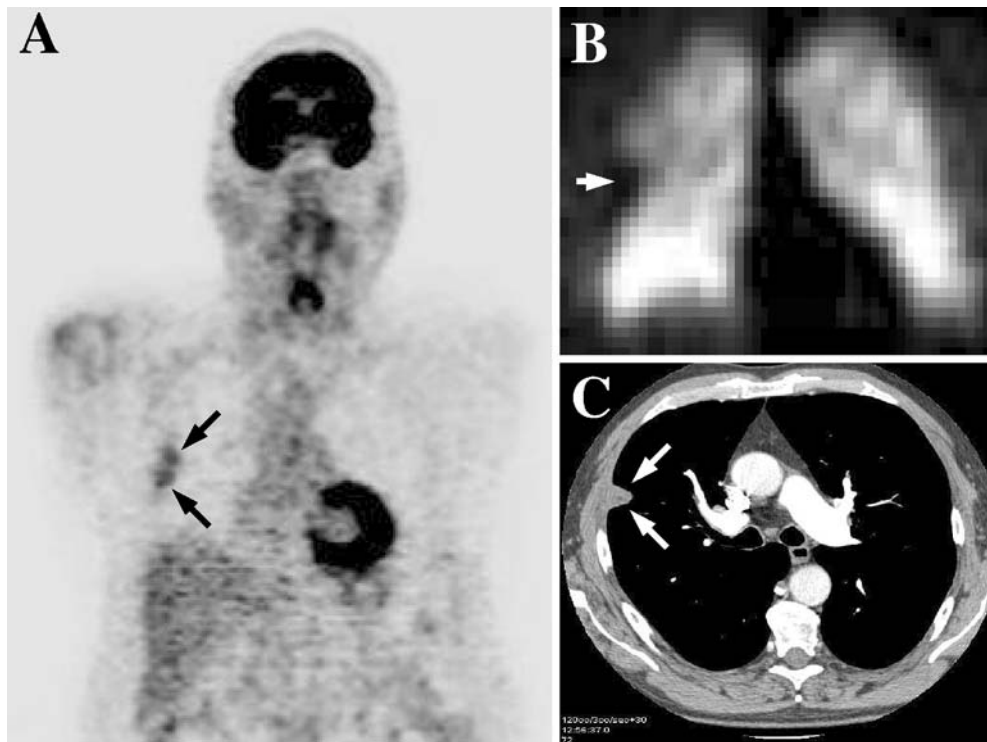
A Coronal FDG PET in a 71-year-old male patient, known to have chronic thromboembolic lung disease, showing peripheral FDG accumulation in the upper lobe of the right lung (arrows; SUV_{max} 3.3). B Correlative subsegmental perfusion defect (arrow)
